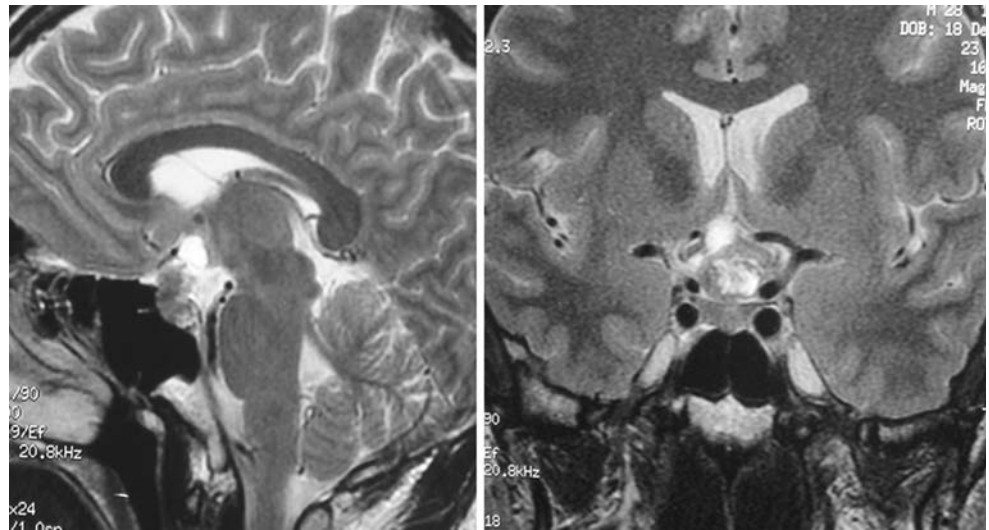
MRI sagittal (*left*) and coronal (*right*) T1WI views. Note involvement of the optic chiasm
